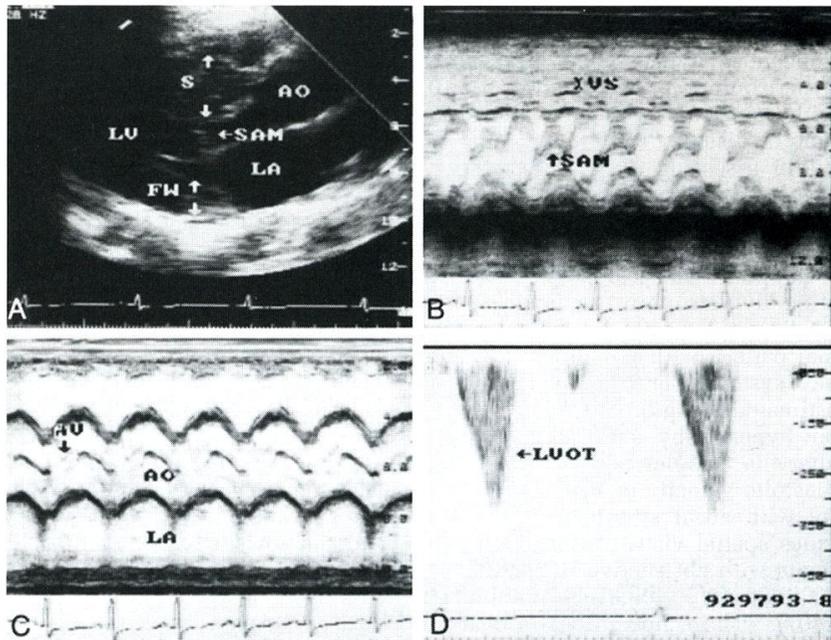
Two-dimensional, M-mode, and Doppler studies in a patient with hypertrophic obstructive cardiomyopathy. The 2-D long-axis study shows the thickened interventricular septum (5) and the systolic anterior motion of the mitral valve (SAM). The abnormal mitral motion and the thickened septum are also seen on the M-mode recording (B). The M-mode recording of the aortic valve shows mid-systolic closure (AV). The Doppler recording of the left ventricular outflow tract shows how the velocity within the outflow tract increases in the latter half of systole. LV = left
